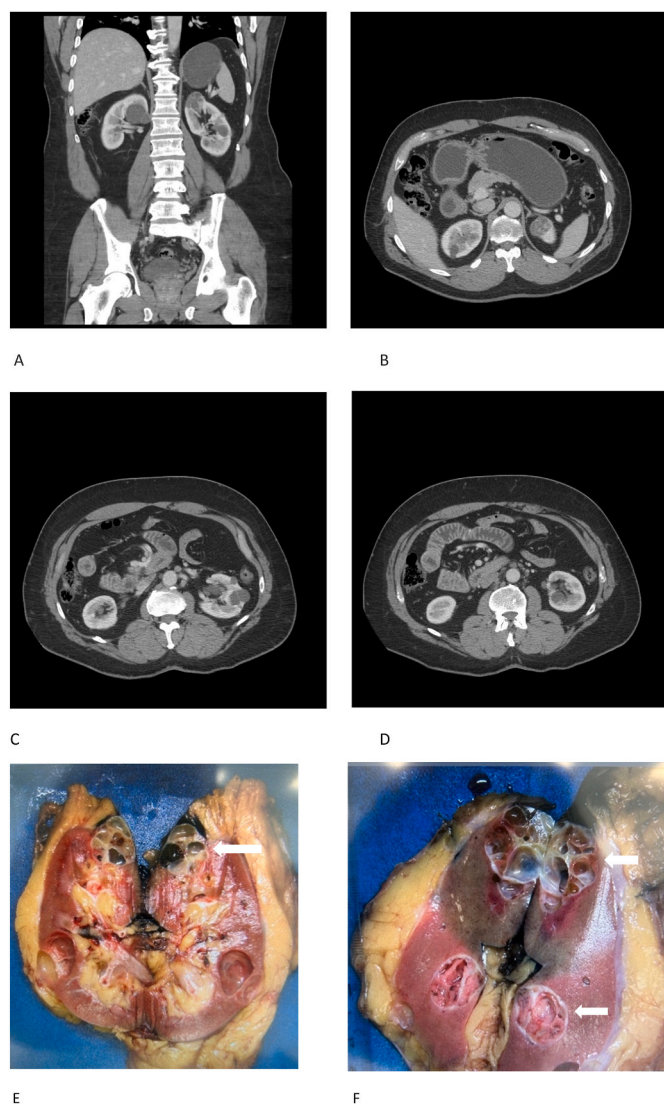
CT scan of the abdomen and pelvis, with contrast and gross pictures of the kidney
